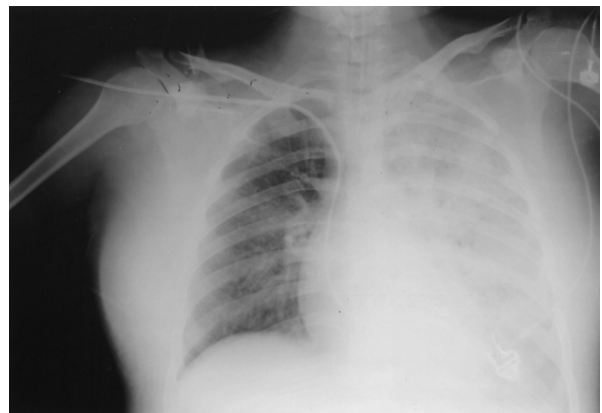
Anterior-posterior chest radiograph reveals diffuse infiltrates in the left lung field when hemoptysis and dyspnea progressed to respiratory failure.
